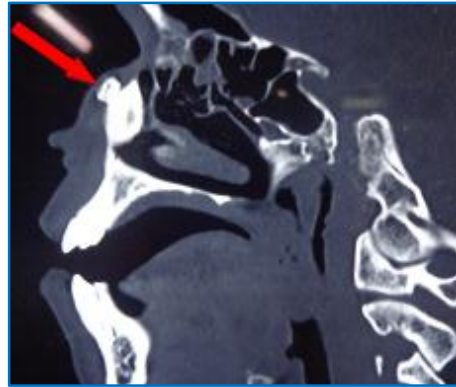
Saggital view of CT scan showing radiopacity on lateral side of nasal bone
